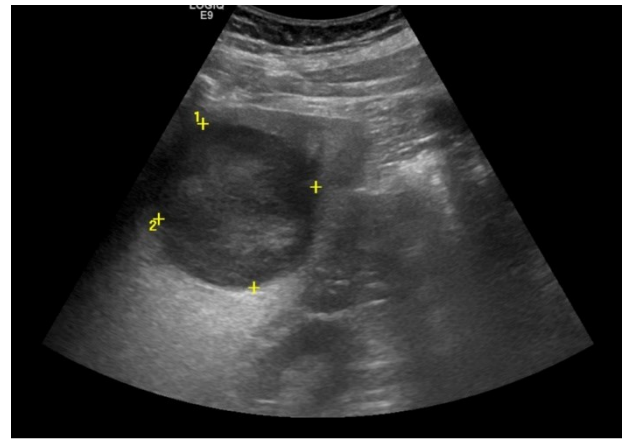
a.34. Steatotic liver, hypoechoic lesion in segment VI, intercostal approach (markers) - CEUS and MRI - HCA
